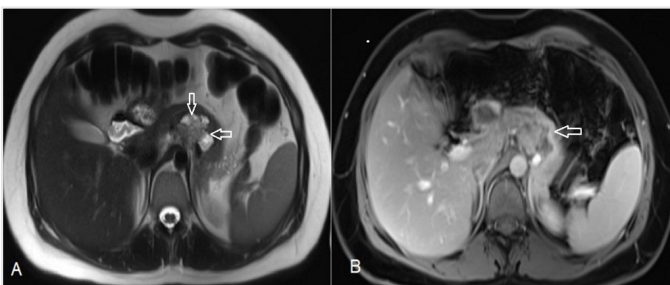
A) Axial T2-weighted image of a solid component of the mass (arrows). B) Venous phase contrast-enhanced T1-weighted image showing contrast enhancement of the mass with extrapancreatic extension (arrow)
